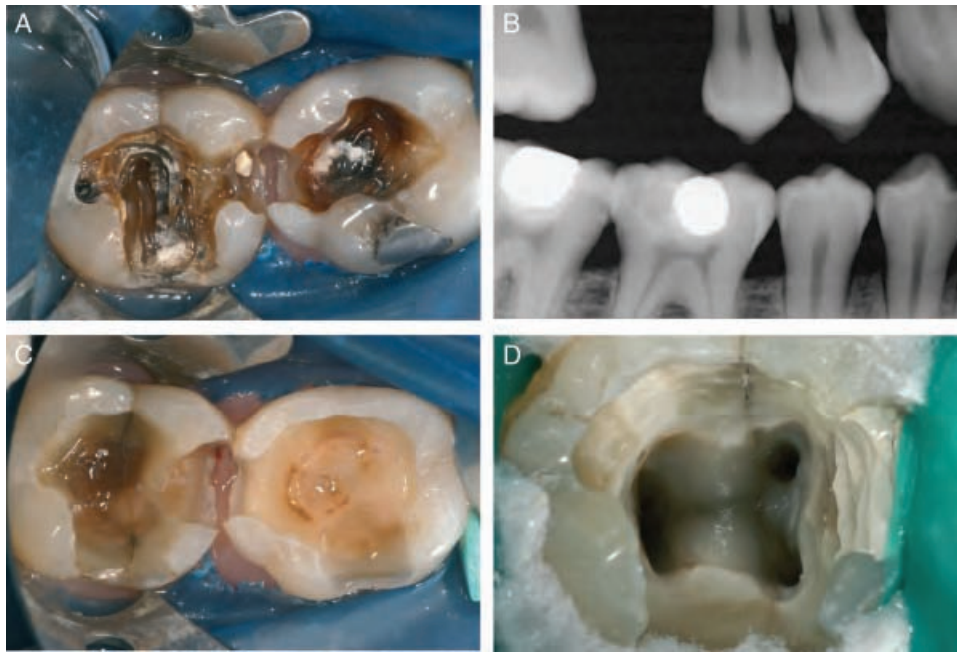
The case is a 40-year-old man presenting with severe pain to chewing in the mandibular right quadrant. A bite-wing radiograph displayed amalgam restorations and recurrent caries (B). It was decided to remove restorations to evaluate the residual dentine. After anesthesia, isolation, and removal of filling material, large quantities of carious tissue appeared (A). A fracture also crossing in a bucco-lingual direction appeared on the floor of tooth #47 (C). In order to explore the depth of the fracture, the pulp chamber was opened and revealed involvement of the pulp chamber floor (D), which cautioned the option of attempting a conservative treatment. The tooth was extracted.
